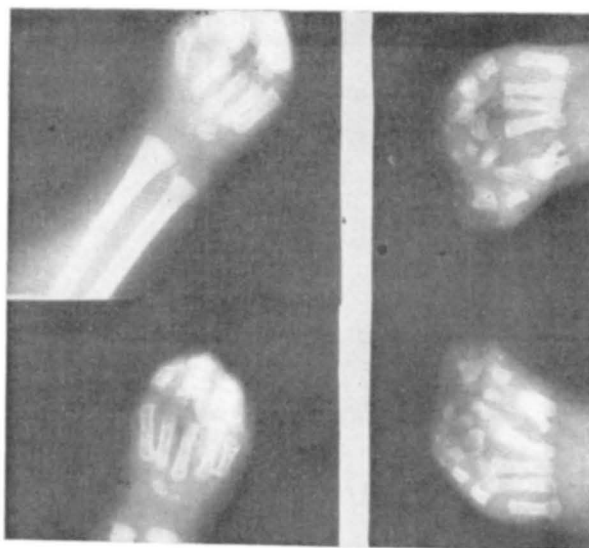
A. X-Ray hands. Shows osseous syndactyly between first second and between third and fourth finger phalanges in one hand; between thumb and second finger and between third, fourth and fifth finger phalanges in the second hand.
